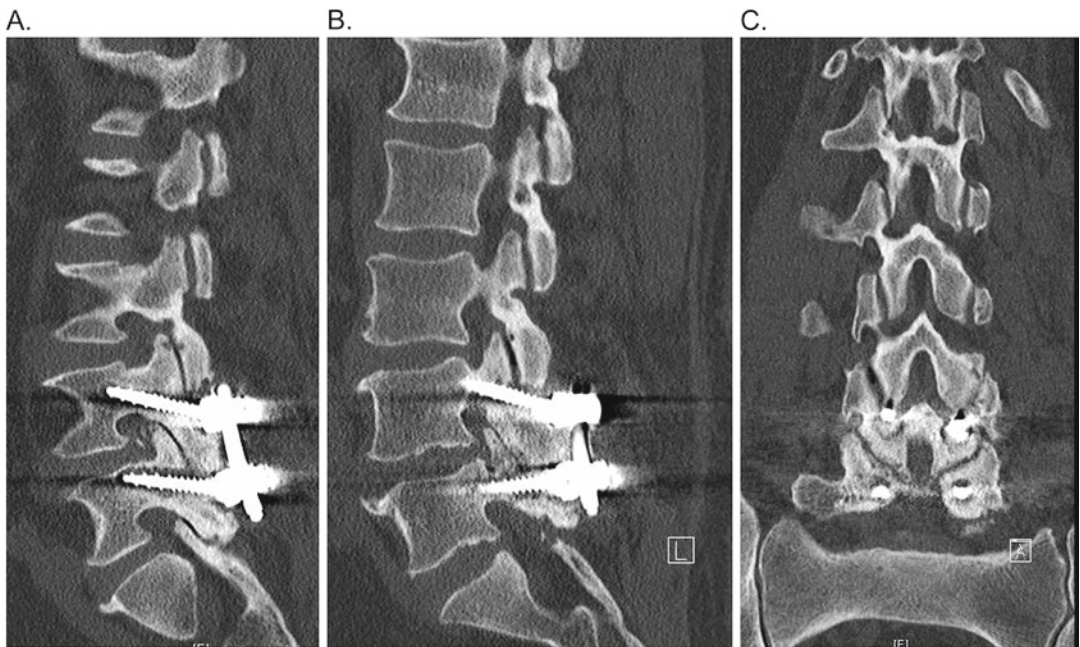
Pre-revision (a, b) sagittal and (c) coronal CT scan demonstrating radiolucency surrounding the L4 and L5 pedicle screws and an L4–L5 pseudarthrosis
